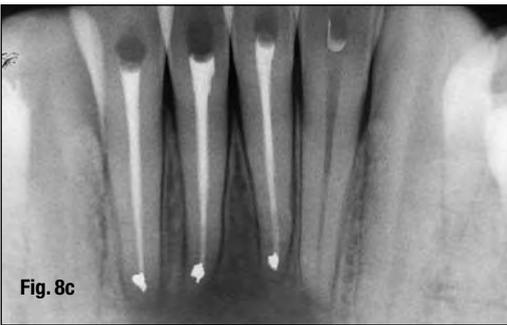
8c_Postoperative radiograph. Three apicoectomies with amalgam retrofilling have been performed. Not the least attention has been paid to removal of all the granulation tissue or to curettage of the surrounding bone or apices, or to removal of the fistulous tract, or even to circular incision of the cutaneous orifice of the fistula.
